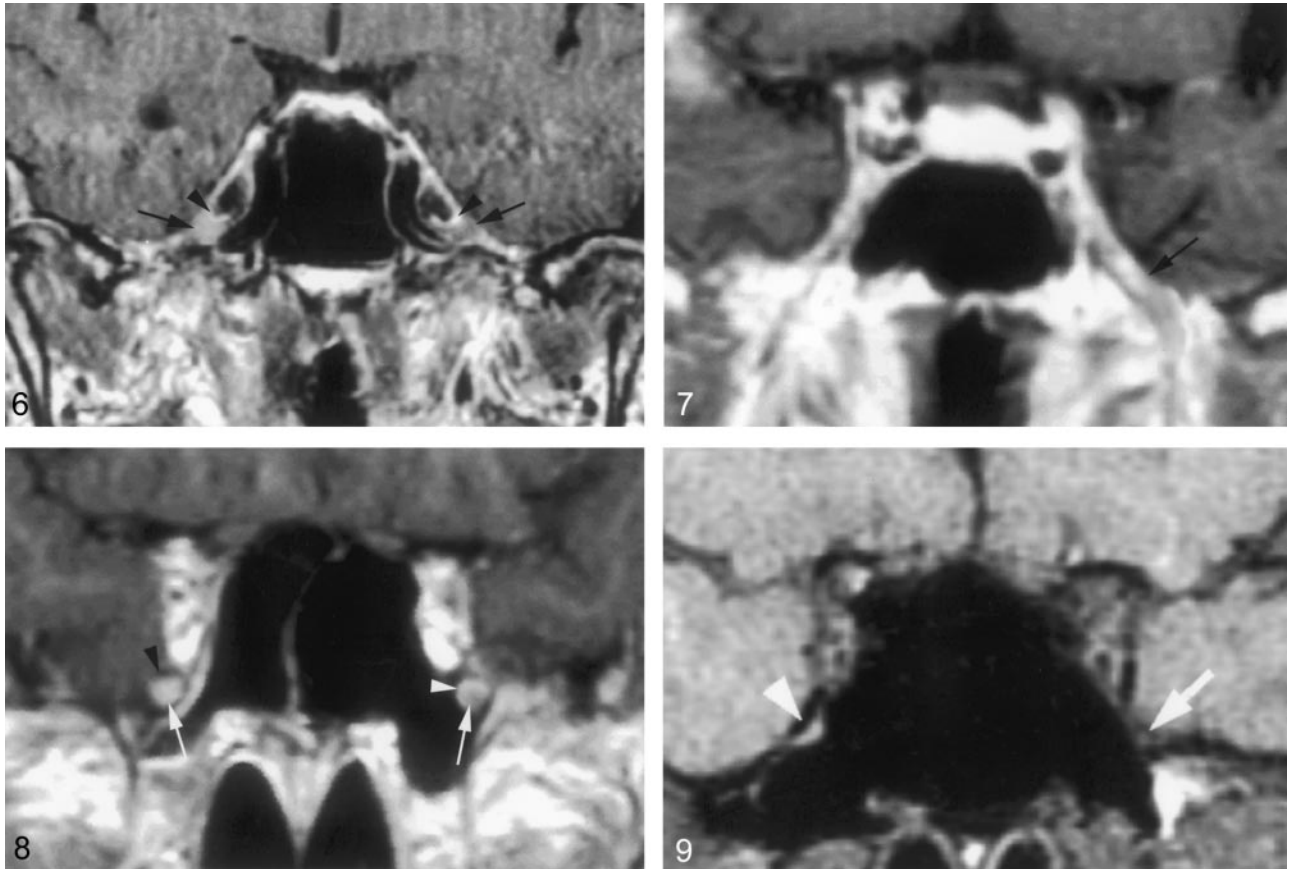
Coronal gadolinium-enhanced T1-weighted image (TR/TE/NEX, 400/15/2) suggests a significantly enhancing right trigeminal ganglion (*right arrow*). The perineural venous plexus (*right arrowhead*) and the trigeminal ganglion cannot be identified as separate structures. This appearance is thought to be due to obscuration of the ganglion by a more extensive perineural venous plexus than that typically seen. The subject did not have any symptoms related to trigeminal nerve or a history of malignancy. Therefore, this is considered a normal variation in imaging appearance. The contralateral side demonstrates the typical appearance of the trigeminal ganglion (*left arrow*) and of adjacent venous plexus (*left arrowhead*).
